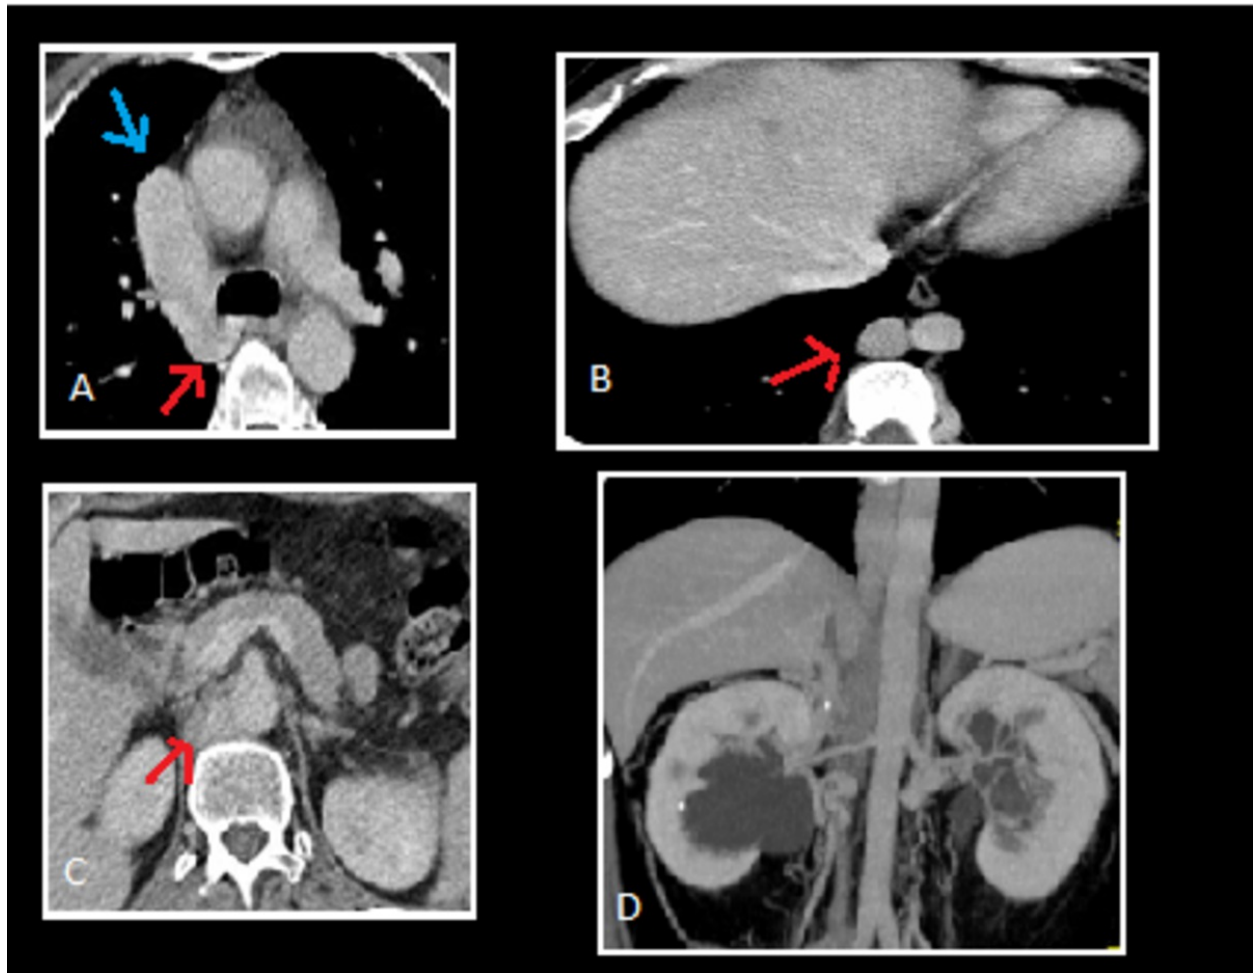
Interruption of the IVC with azygos continuation. CT images shows: (A) enlarged azygos vein (red arrow) draining into the superior vena cava (blue arrow). (B and C) the vessel parallel to the aorta under the crus is the azygos vein (red arrow). (D) Absence of IVC in its normal location.
